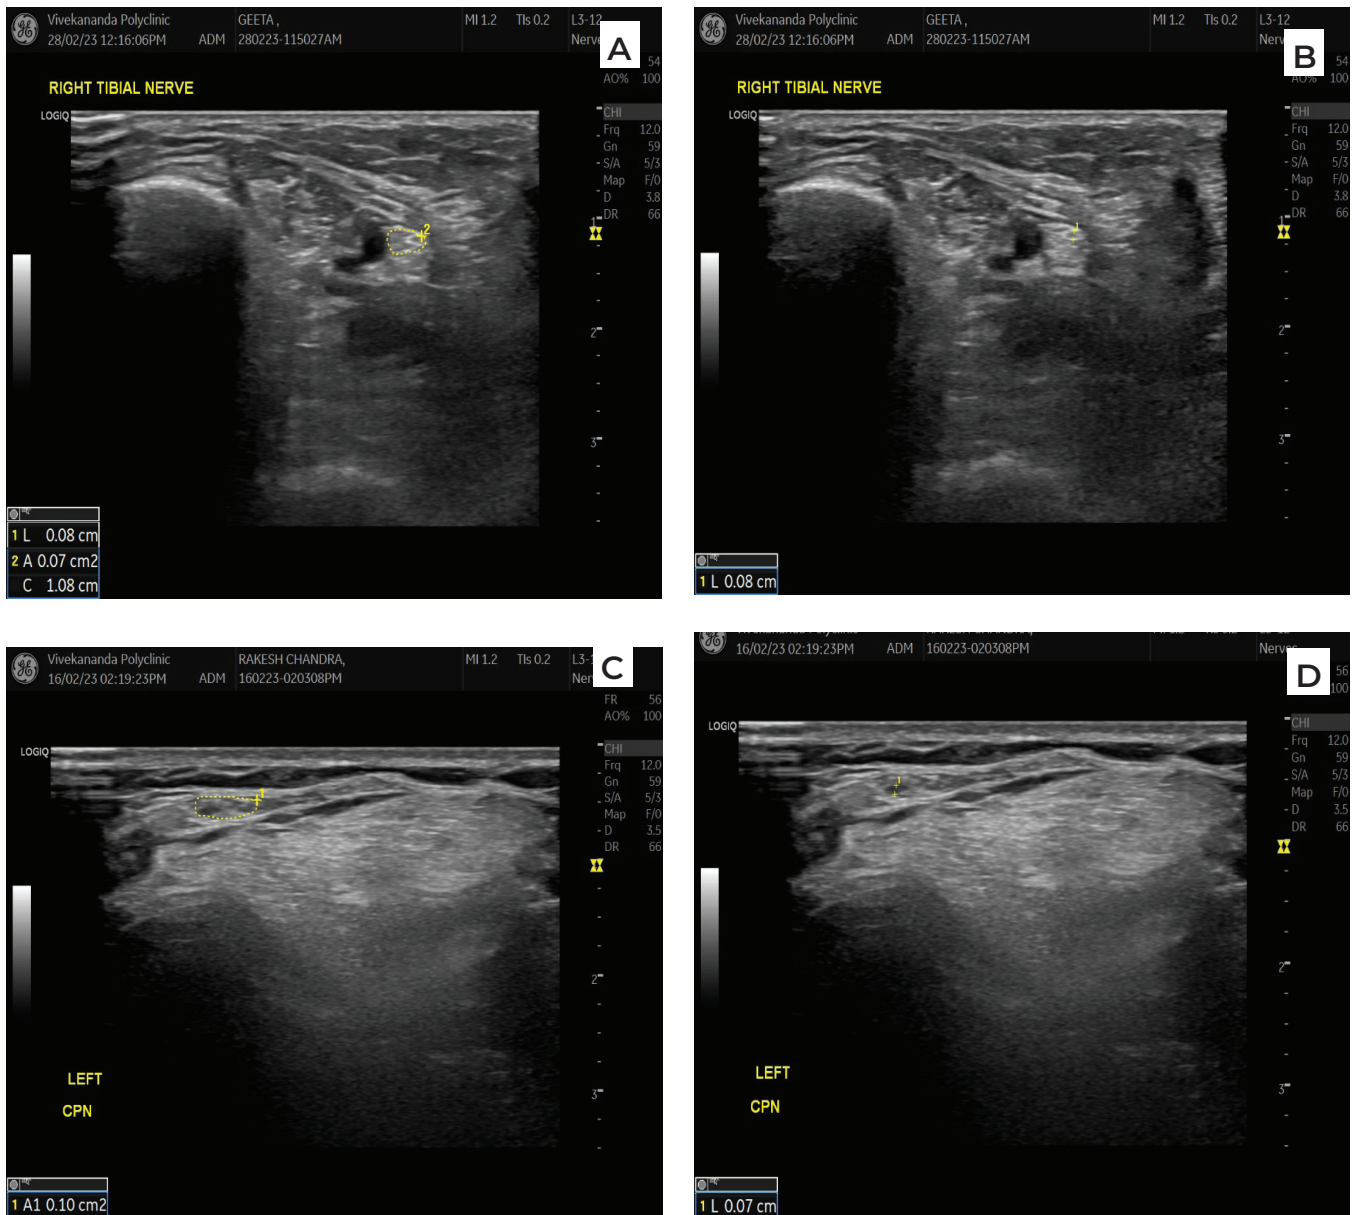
Case 1- A 45-years-old female patient diagnosed with Type-2 Diabetes Mellitus 10-years back. The patient did not have any neuropathic symptoms. Her HbA1c was 7.9% and RBS was 250 mg/dL. A. A transverse sonogram view of the tibial nerve at 3 cm proximal to Medial Malleolus (MM) showing normal Tibial nerve with Cross section area (CSA), measuring 7 mm². CSA was measured using a continuous trace method. B. Mean Thickness of Nerve Fascicle (MTNF) of tibial nerve was increased measuring 8 mm. C. A transverse sonogram view of Common Peroneal Nerve (CPN) at fibular neck level showing thickened nerve with CSA of 10 mm². D. Mean Thickness of Nerve Fascicle (MTNF) of Common Peroneal Nerve (CPN) was increased measuring 7 mm.
